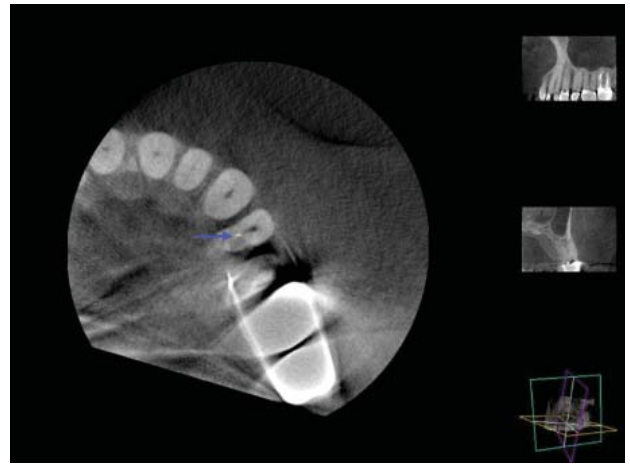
The CBCT scan shows the buccal canal enlarged and a marker of gutta-percha placed (see arrow) to determine the accuracy of the pathway to the palatal canal.
